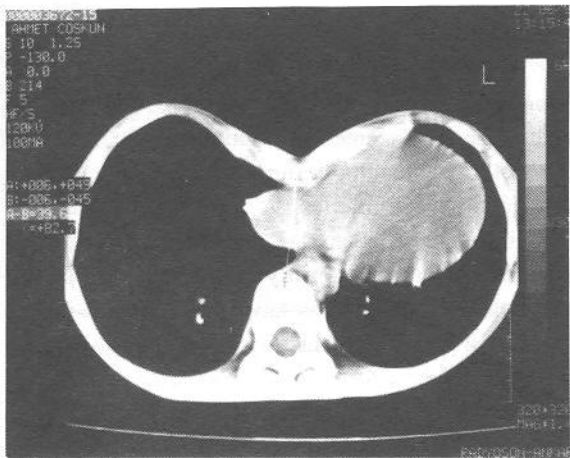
a) Preoperative external appearance, b) chest CT of a patient.
